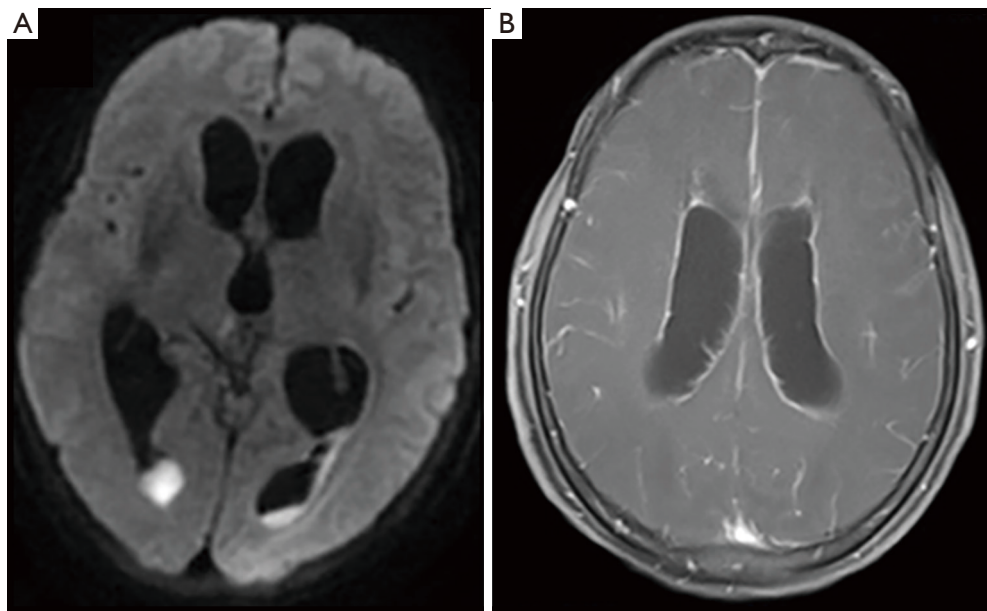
MRI findings. (A) The diffusion-weighted magnetic resonance imaging showed irregular intraventricular debris with restricted diffusion in occipital horns with a dilatation of all the ventricles. (B) Contrast-enhanced MRI showed abnormal enhancement of bilateral ependymal. MRI, magnetic resonance imaging.
